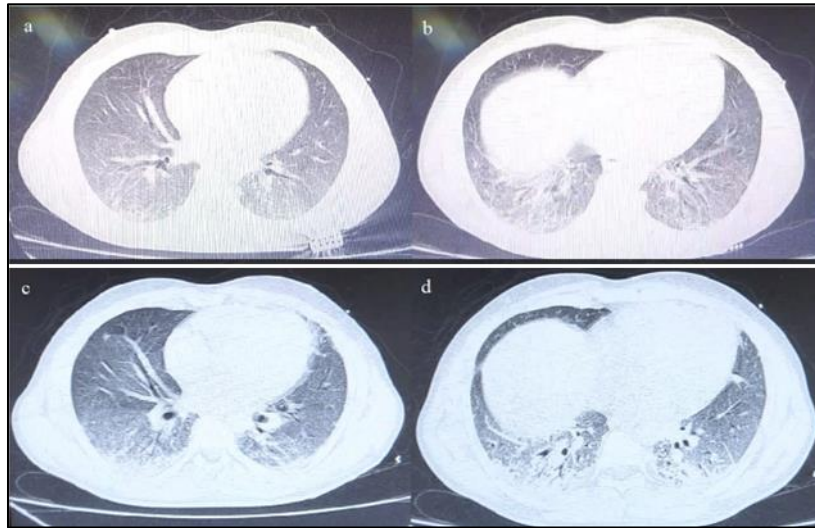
CT scan of the chest on day 4 (a & b) showing bilateral lower lobes reticulo-nodular infiltrates with ground glass opacities (GGOs) and 13 days after his admission (c & d) showing more extensive and diffuse GGOs with bilateral lower lobes consolidations and reticular infiltrates
